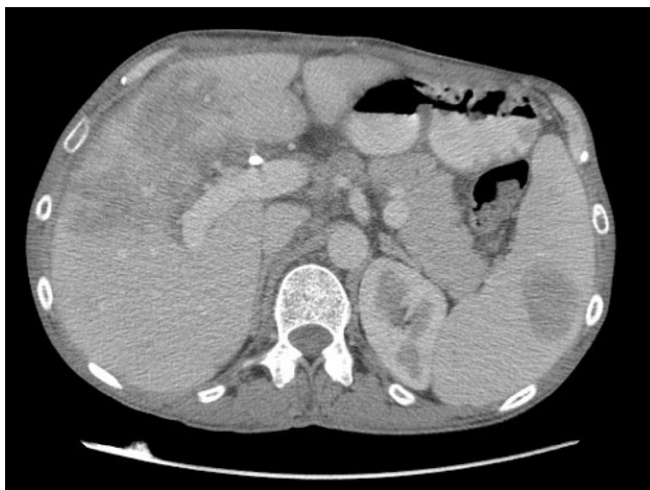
Abdominal CT in portal venous phase shows hepatosplenomegaly with markedly heterogenous perfusion of the liver and large focal lesion within the spleen.
